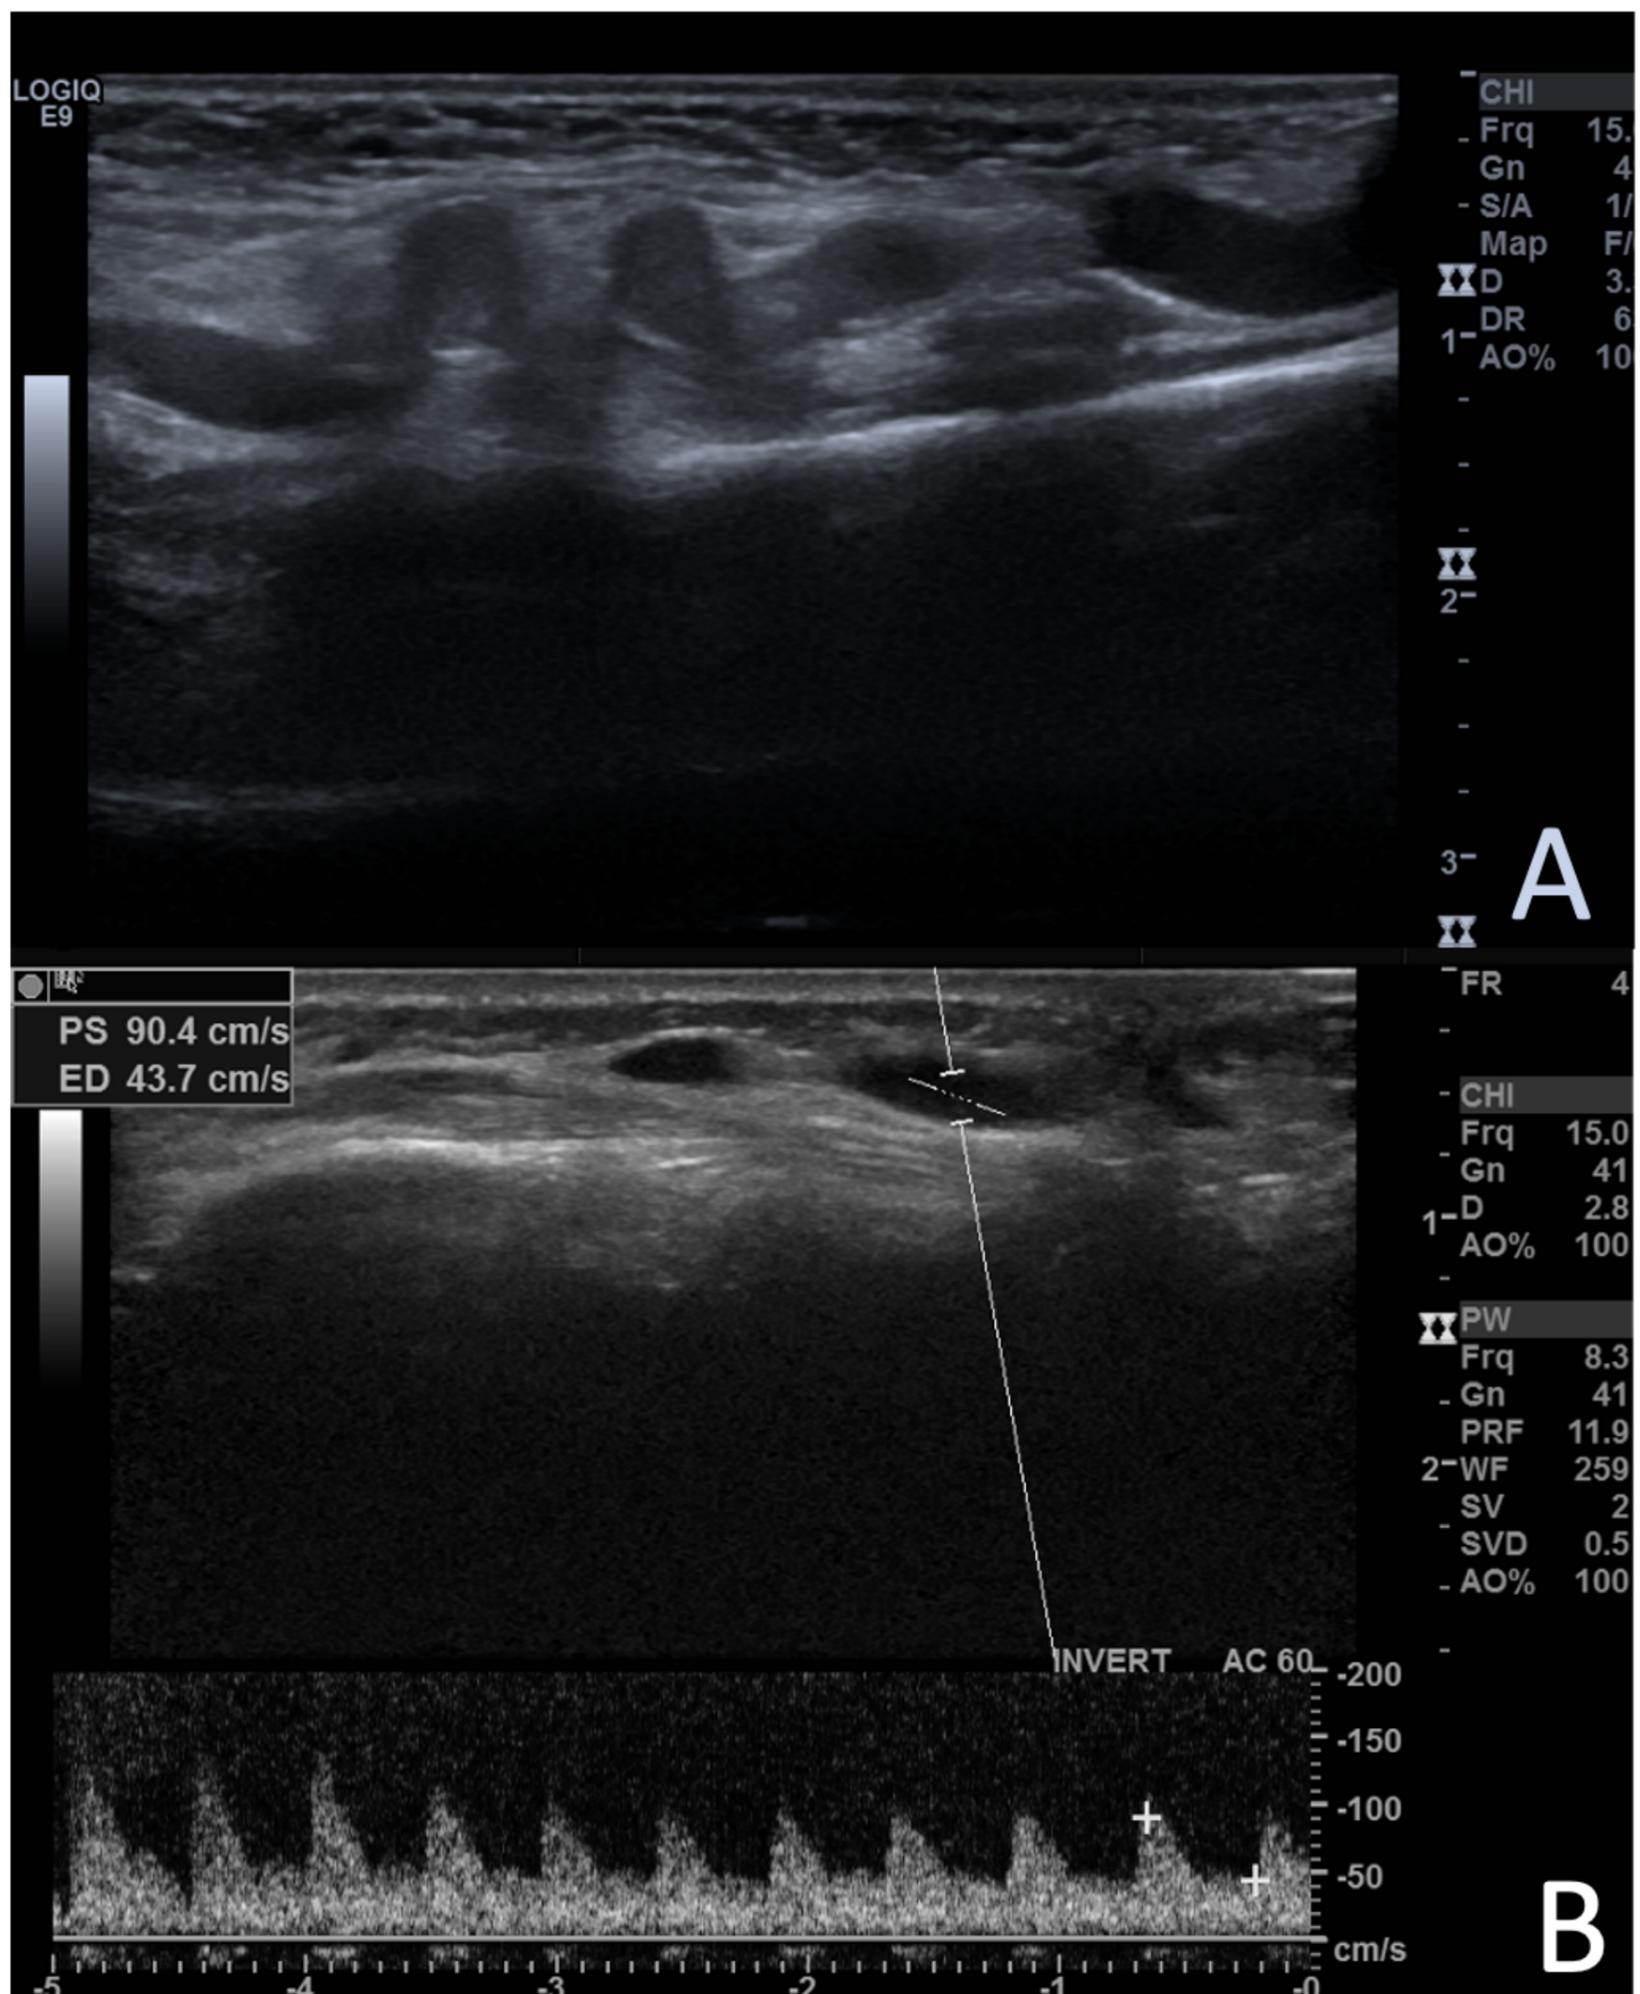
(A,B) Color Doppler ultrasonography of the right wrist revealed a large communication channel between the radial artery and the cephalic vein at the level of the antecubital fossa. There was turbulent blood flow. The artery was markedly enlarged.
